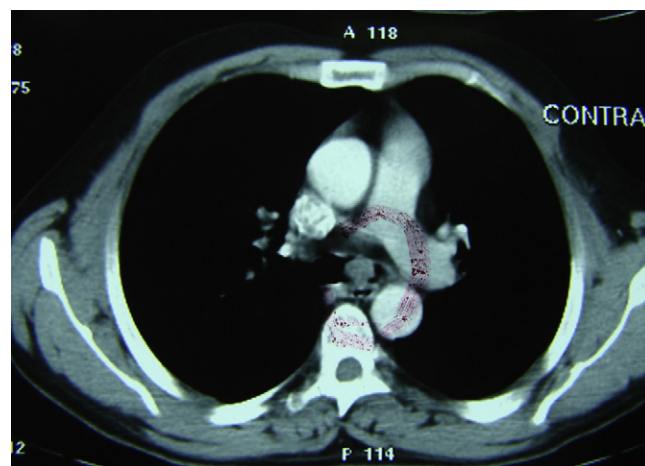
Preoperative chest CT scan (transverse section).
